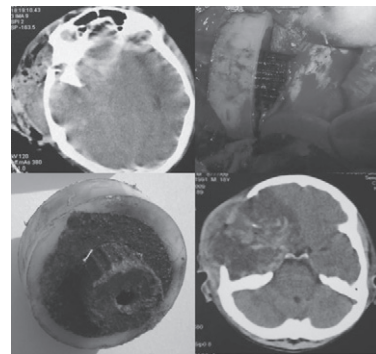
Pre- and post-operative CT brain in a case of non-metallic missile injury showing white plastic tear gas shell (51 mm diameter) in brain and after removal.
